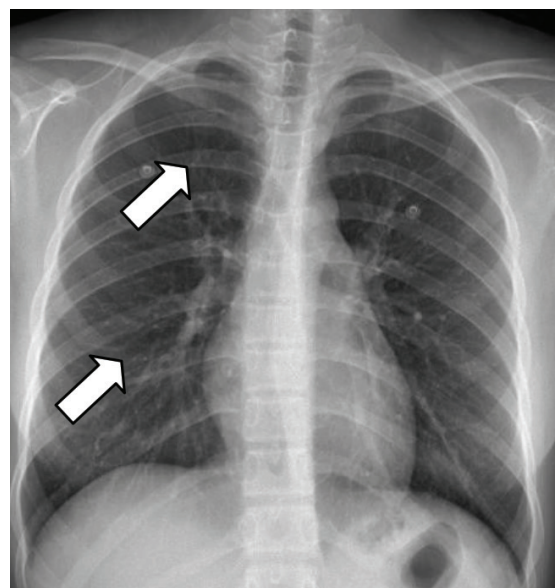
Chest radiograph showing suspicious nodular opacities at the right upper lung and right lower lung
